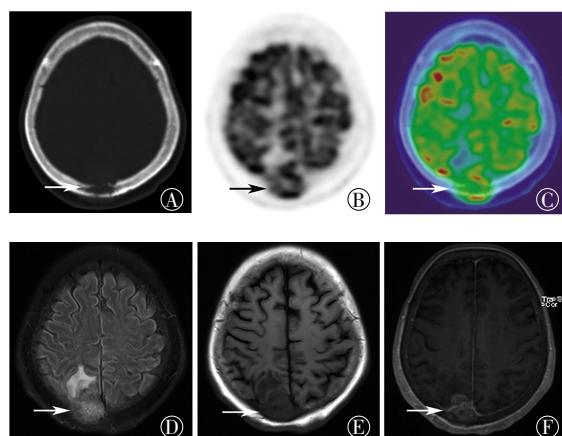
患者女性，63 岁，宫颈小细胞神经内分泌癌颅骨转移 <sup>18</sup>F-FDG PET/CT 及 MRI 图像 图中，A~C：右颅顶部病灶轴位 CT、PET 及 PET/CT 融合图像，CT 平扫骨窗示颅顶骨骨质破坏，PET 示代谢异常增高，SUV<sub>max</sub> 为 16.4(箭头示病灶)；D~F：右颅顶部病灶 MRI 图像，D 为 T2-Flair 序列，E 为 T1-Flair 序列，右顶叶见稍长 T2、T1 信号结节影，周围脑实质内见长 T2 信号水肿带，病灶侵及邻近颅骨，F 为 MRI 增强扫描，示病灶呈明显强化(箭头示病灶)。FDG：氟脱氧葡萄糖；PET：正电子发射断层显像术；CT：计算机体层摄影术；MRI：磁共振成像；SUV<sub>max</sub>：最大标准化摄取值；Flair 序列：液体衰减反转恢复序列。
